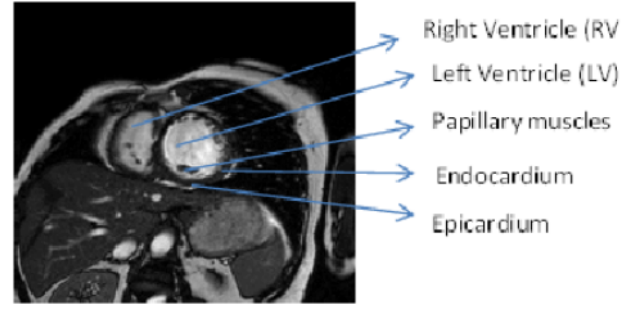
Left ventricle in a short-axis MRI image
